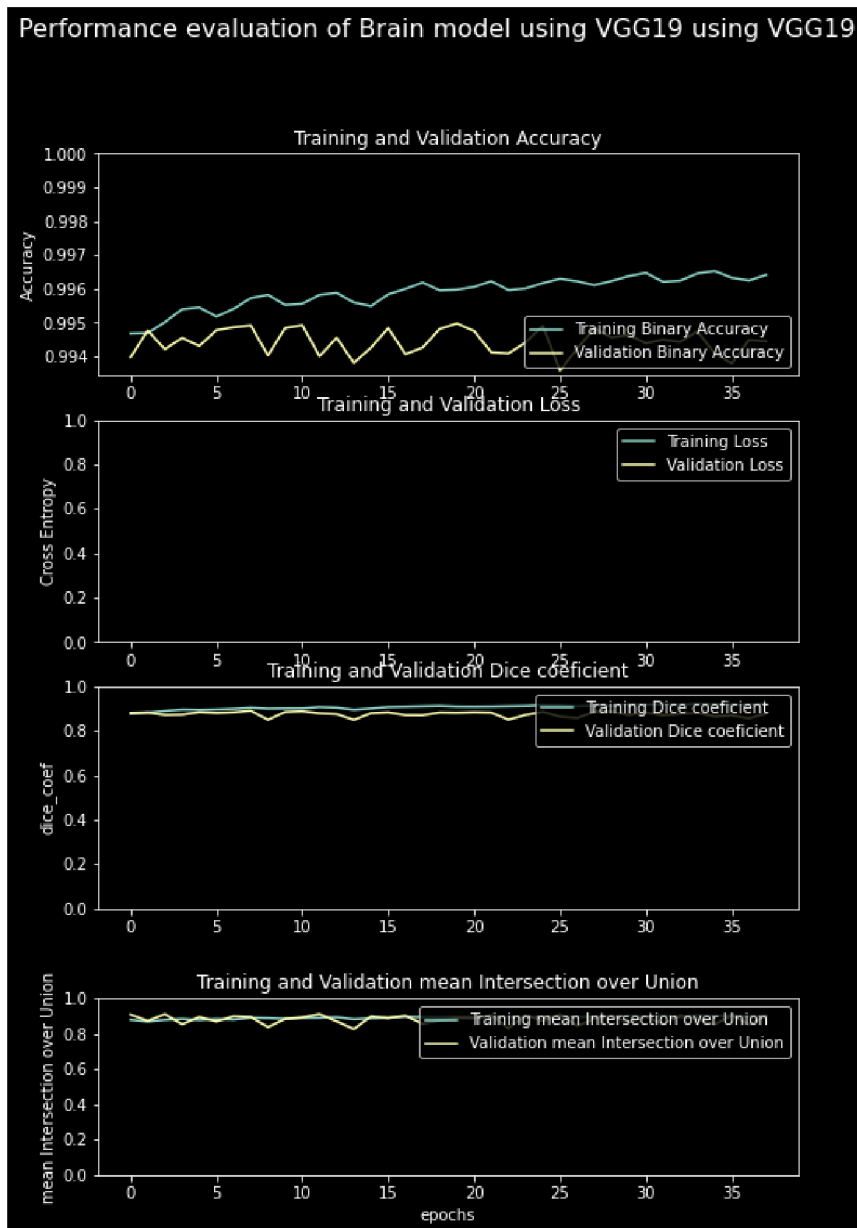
Performance of the custom u-net model using VGG19 on Brain MRI images. Note the epoch (abscise) graduation with 1 unit = 10 epochs to show the different intersections of the learning and validation curves due to the gradual change in the learning rate up to 0.0001. (Own work)
